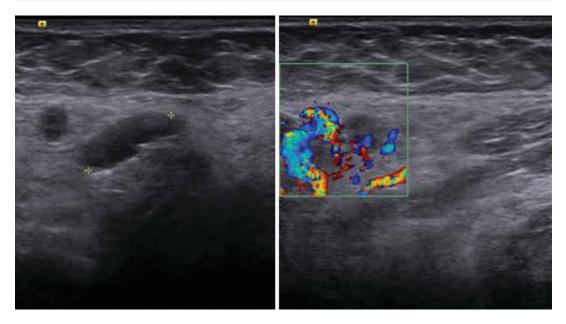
Primary intraosseous carcinoma. (a) USG shows fusiform shape in submandibular lymph nodes. (b) Color Doppler reveals peripheral vascularity of the lymph node which can be a precursor for metastasis
